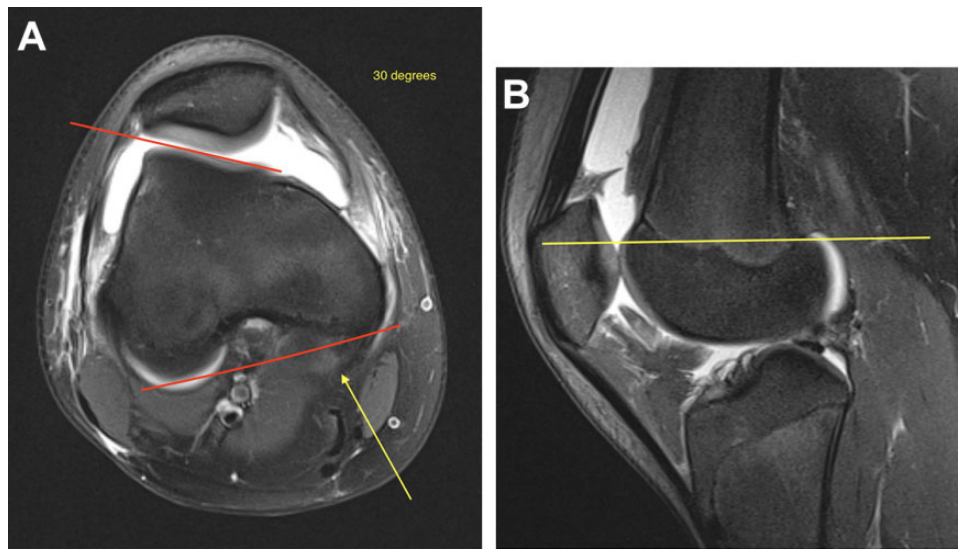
(A) Measurement technique for single-image lateral trochlear inclination (LTI). The angle, represented by the red lines, was determined between the most proximal aspect of trochlear cartilage and the posterior femur on an axial MRI image. Here, the LTI measured 30° . Because the apex of the angle was medial, the angle was assigned a positive value. On this image, the medial aspect of the posterior femur was somewhat ambiguous, and it was not clear where the measurement of the posterior femur should be. An arrow (yellow) highlights what appeared to be the developing posterior medial femoral condyle. This ambiguity could be due to a slight deviation from perfect positioning in the gantry or from small differences in the position of the most superior aspects of the posterior femoral condyles. Regardless, this image highlighted a not uncommon shortcoming of a single-image LTI measurement. (B) Cross-referenced sagittal magnetic resonance imaging scan of the cut with the most proximal extent of trochlear cartilage represented by the yellow line. At this level, the posterior aspect of the femur represented the junction between metaphysis and epiphysis as opposed to fully formed posterior femoral condyles.
